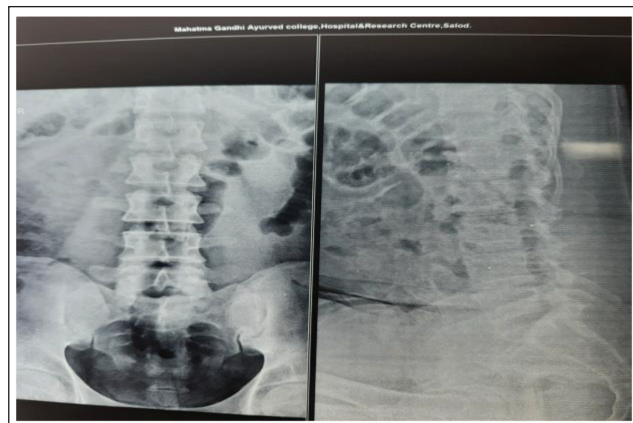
X-ray of Lumbar Joint (Before Treatment).
